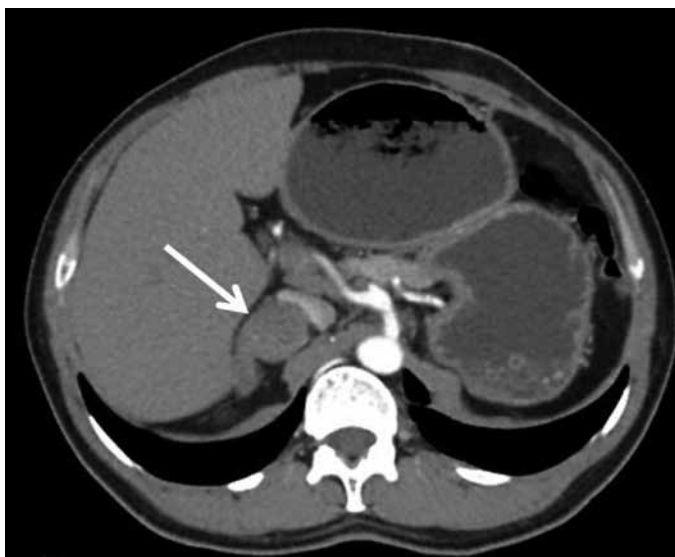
Computed tomography showing an 30 mm, well-circumscribed, enhanced round tumor with solid component arising from the right adrenal gland
